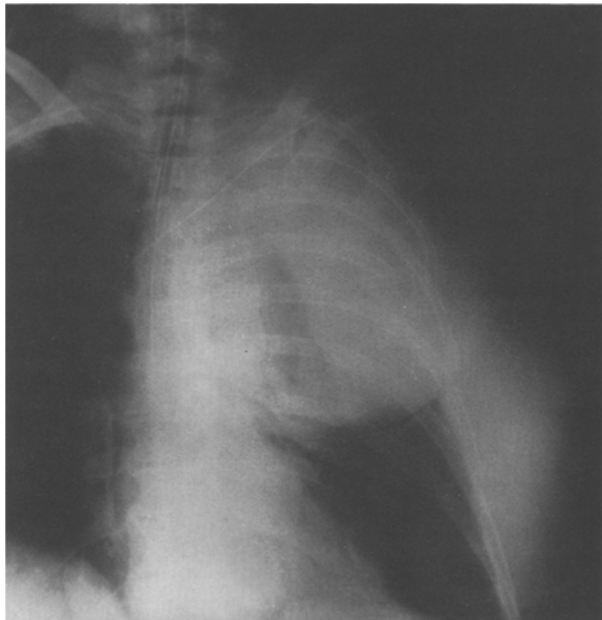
Chest X-ray showing a round white shadow in the left upper lobe, 3 h after insertion of a subclavian catheter
